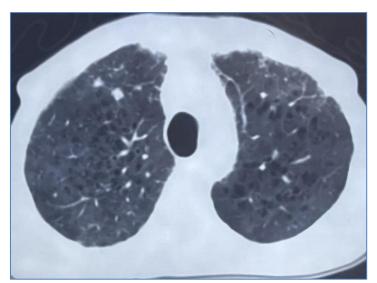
HRCT thorax showing interstitial opacities in bilateral upper lobes anterior aspect with bilateral upper lobe centrilobular emphysema with nodule in right upper lobe
